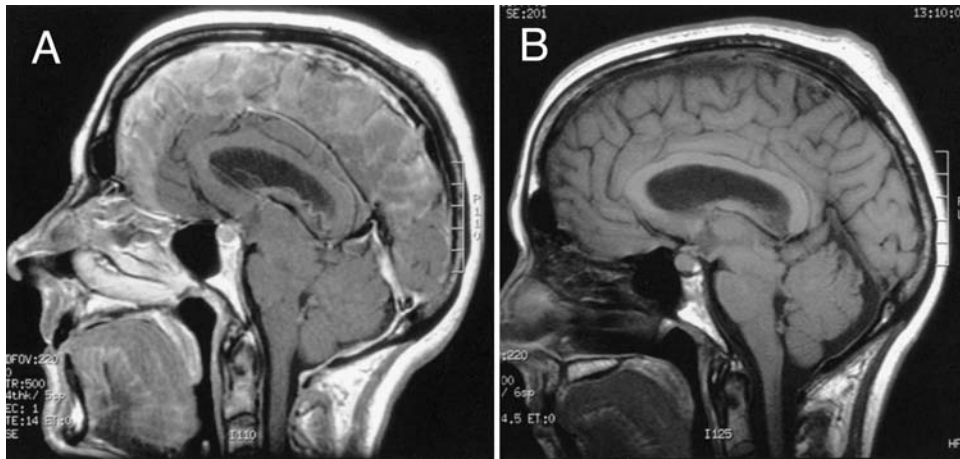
Sagittal MR images. A: Preoperative T<sub>1</sub>-weighted image demonstrating brain sag, effacement of the suprasellar and basal cisterns, and diffuse dural enhancement—classic imaging findings of SIH. B: Postoperative image revealing partial reversal of brain sag and restoration of suprasellar and basal cisterns.
